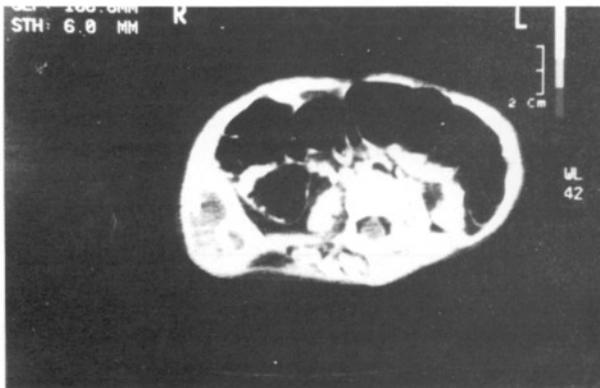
CT of the cystic maas in the abdominal wall at the right flank containing distal tip of the peritoneal catheter.
